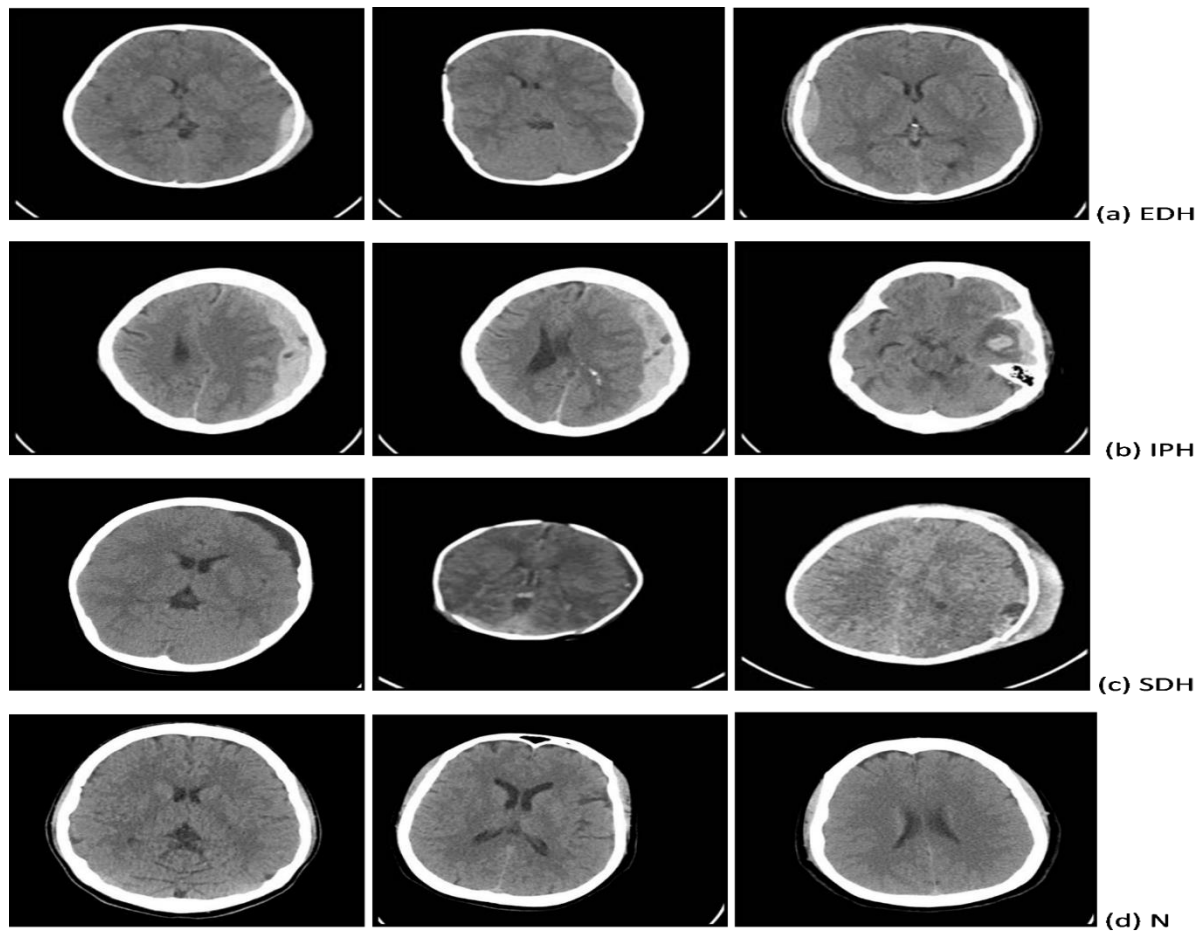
Type of Brain Hemorrhage CT images used in the study
